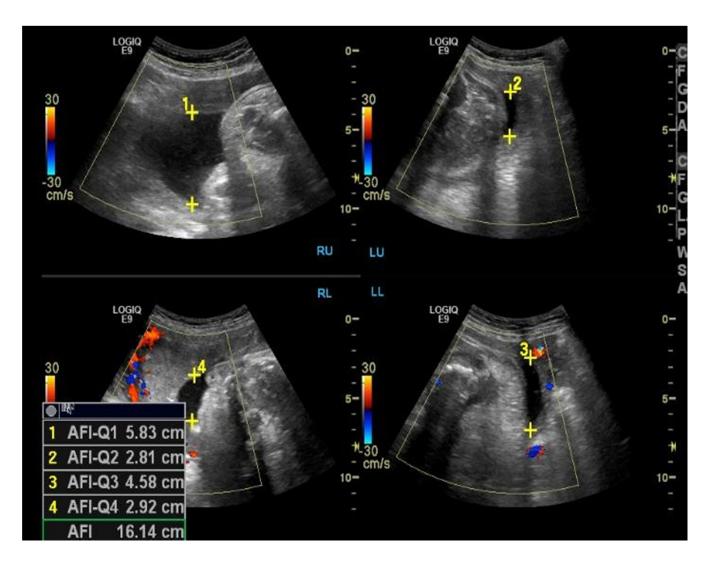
Sonographic image show four quadrant with single deepest vertical measurement for normal AFI (Nabhan, A. F. etal., 2009).
